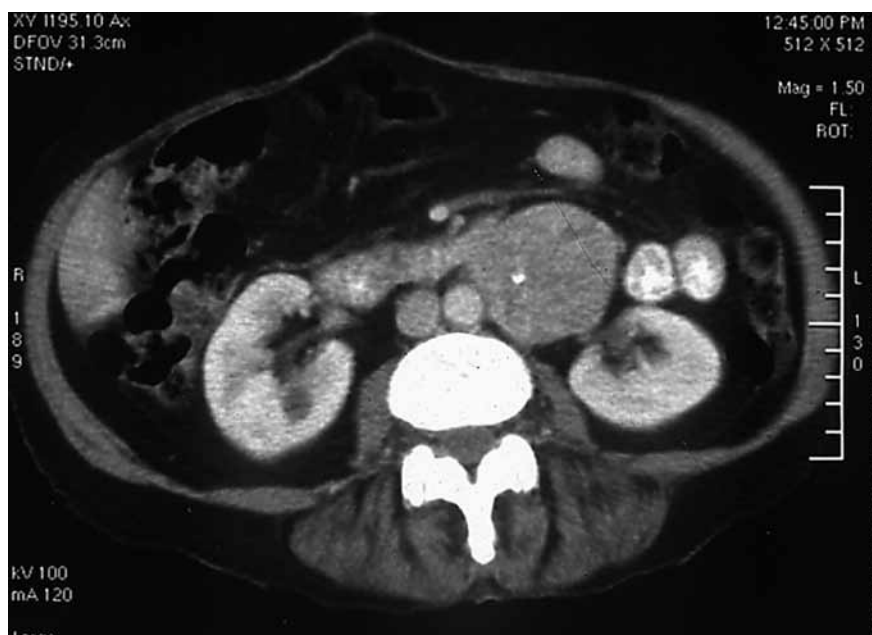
Abdomen CT imaging after surgery.
